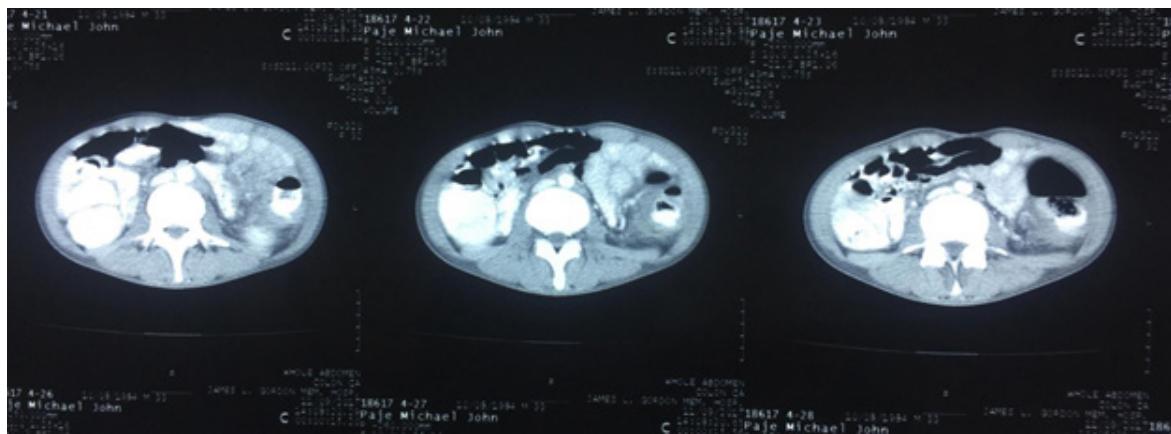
Whole abdominal CT scan with contrast.
